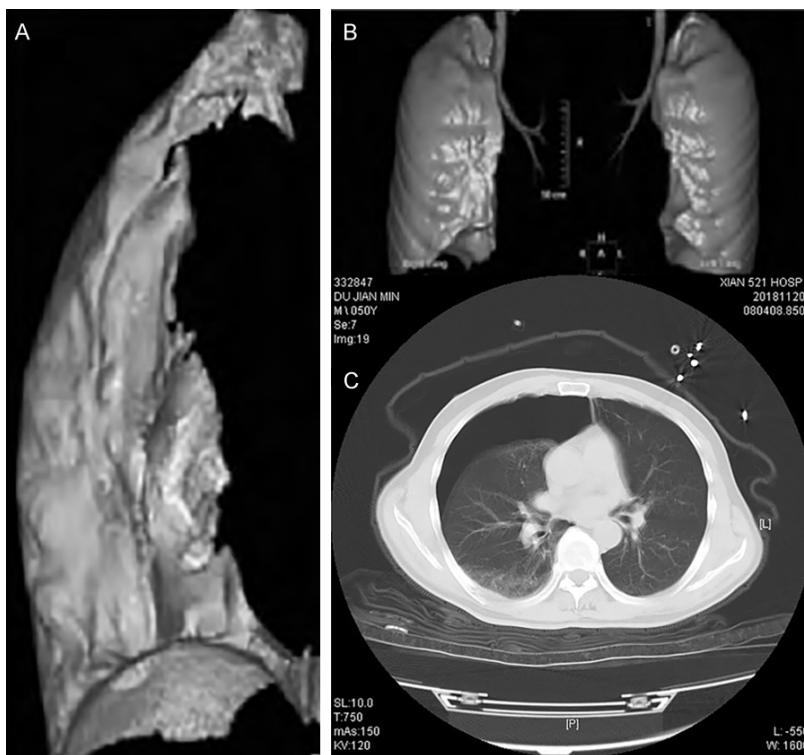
Display of pneumothorax by CT post-processing multiplanar reconstruction and VR. A and B: Multiplanar reconstruction and VR technique respectively; C: The CT plane image. VR: volume rendering.
